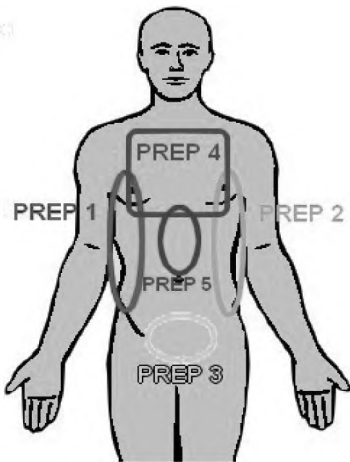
Ultrasound windows according to the 'Polytrauma Rapid Echo-Evaluation Program'
